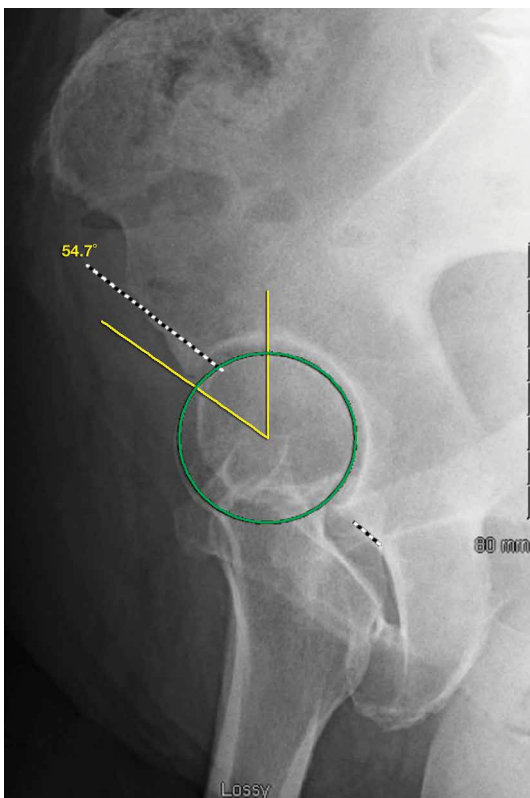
Weight-bearing upright false-profile radiograph of a 47-year-old woman shows anterior coverage of femoral head as well as femoral head–neck junction and femoroacetabular congruency. On radiograph, quantitative measure is anterior center-edge angle (ACEA), or angle formed by 2 lines from center point of femoral head. One line is straight vertical radius of circle; other is oblique line to anterior-most aspect of acetabular sourcil. In this case, ACEA is 55° (normal, $>20^\circ$). Femoroacetabular joint is congruent.
